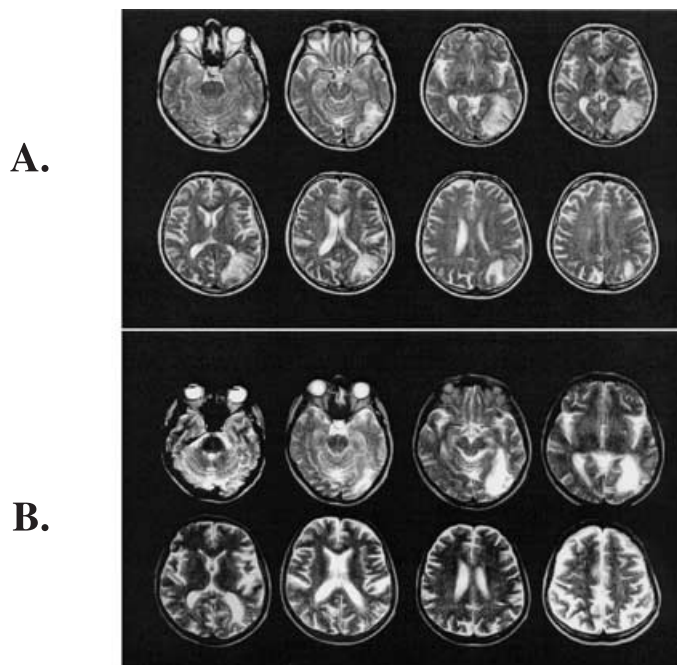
Lesion location. A. Depiction of left hemispheric brain damage caused by bleeding of probable hypertensive origin. T2 weighted MRI five years prior to paroxysmal body illusions (1996). The lesion includes the posterior part of the superior and middle temporal gyrus as well as the angular gyrus and the parieto-occipital junction. B. T2-weighted MRI showing brain damage during the actual symptomatology (2001). Note the absence of more recent brain damage and cortico-cortical atrophy in the left posterior hemisphere.
